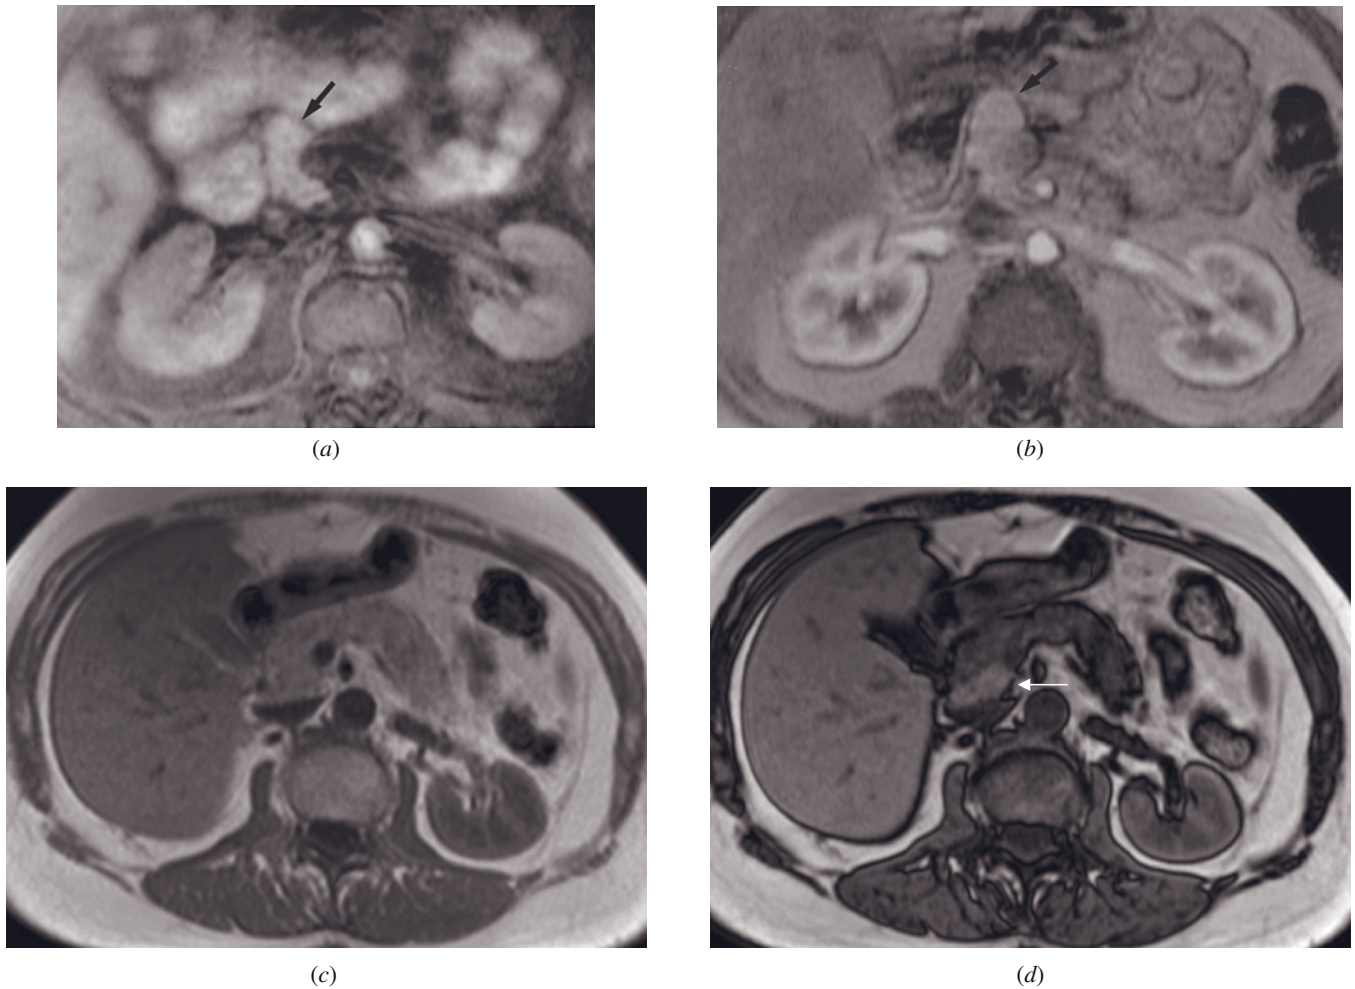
Absence of the dorsal pancreas anlage. T1-weighted fat-suppressed spin-echo (*a*) and immediate postgadolinium T1-weighted SGE (*b*) images. A normal-appearing head of the pancreas is apparent. The pancreas terminates with a rounded contour (arrow, *a, b*) at the level of the pancreatic neck.
